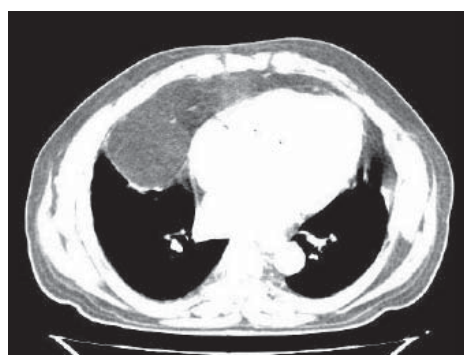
A preoperative thorax CT image.
